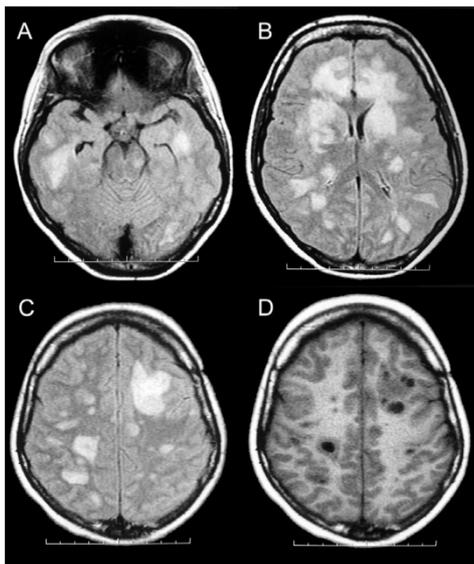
Initial brain MRI: axial FLAIR images showing multiple hyperintense lesions (A, B, and C) and an axial T1-weighted image showing some matching hypointense focal areas (D).
